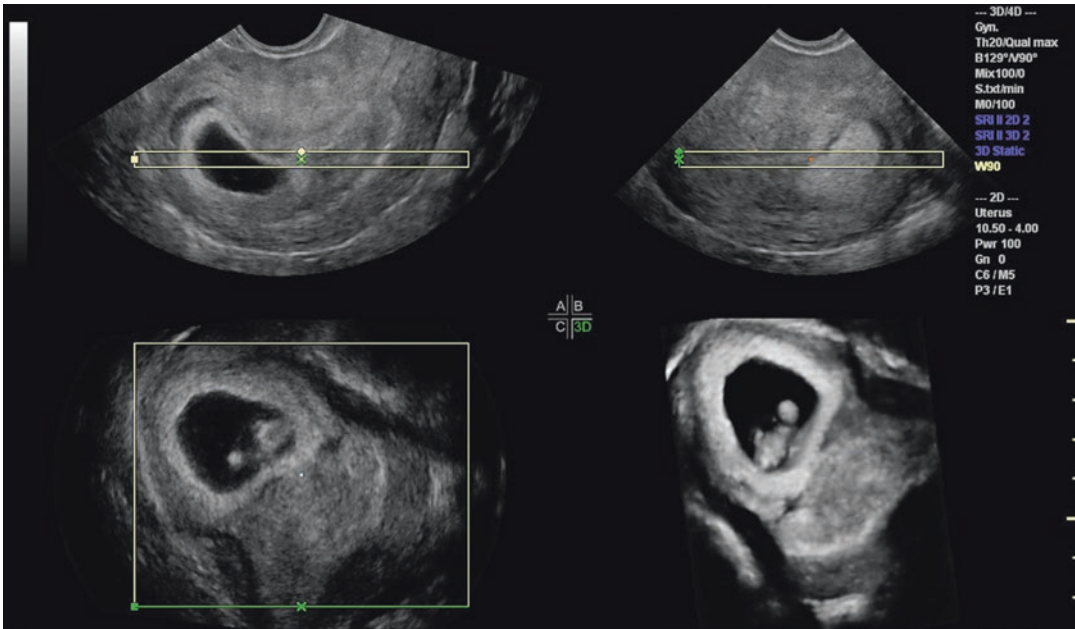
Transvaginal ultrasound: angular pregnancy
